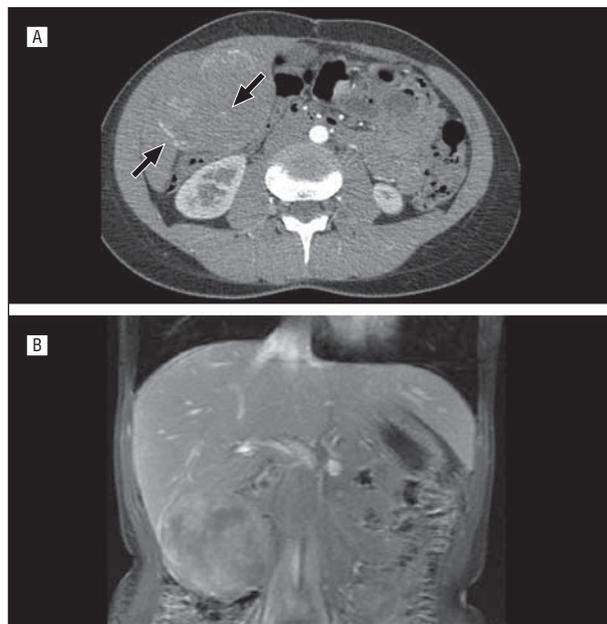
A contrast-enhanced abdominal computed tomographic scan (A) and a hepatic magnetic resonance image (B) showing a large, heterogeneous, solid, capsulated mass. A, Black arrows indicate intratumoral and peritumoral calcifications.
